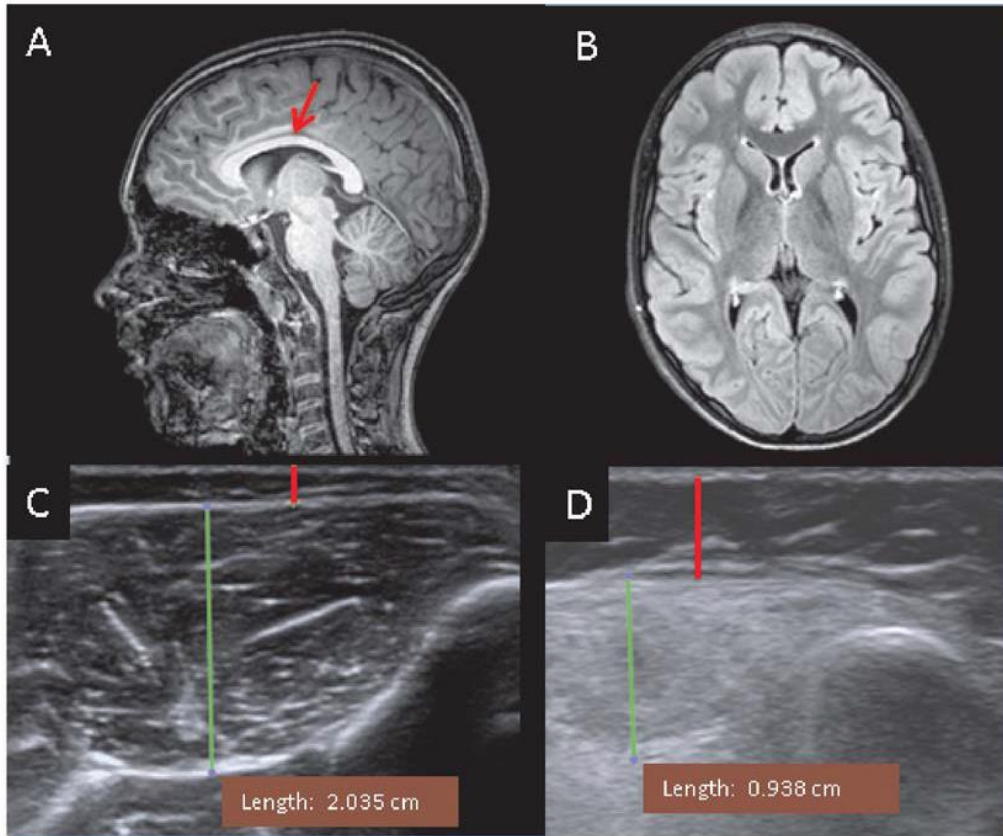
Brain and muscle imaging of a patient with a KCC3 T991A mutation. (A) T1 sequence brain MRI, mid-sagittal view. Corpus callosum is indicated by red arrow. (B) FLAIR sequence brain MRI, axial view, demonstrating normal brain volume. (C) Muscle ultrasound (performed on Siemens AcusonS2000) of the tibialis anterior (TA) muscle from a healthy 10-year-old-boy to represent normal echogenicity and bulk. (D) Abnormal muscle ultrasound of the TA muscle from our patient at 7-years-old. In C and D, the green line indicates depth of muscle, and the red line indicates the subcutaneous fat layer.
